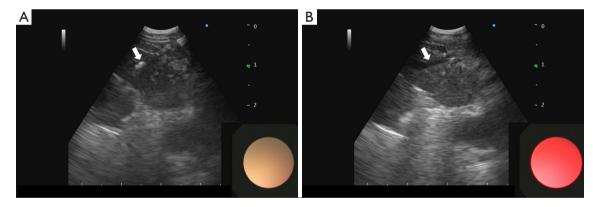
EBUS with utilization of cryoprobe. (A) EBUS visualization of 1.1 mm cryoprobe (white arrow) in lymph node. (B) EBUS visualization of anechoic shadow of 1.1 mm cryoprobe (white arrow) after cryoextraction of lymph node biopsy. EBUS, endobronchial ultrasound.
